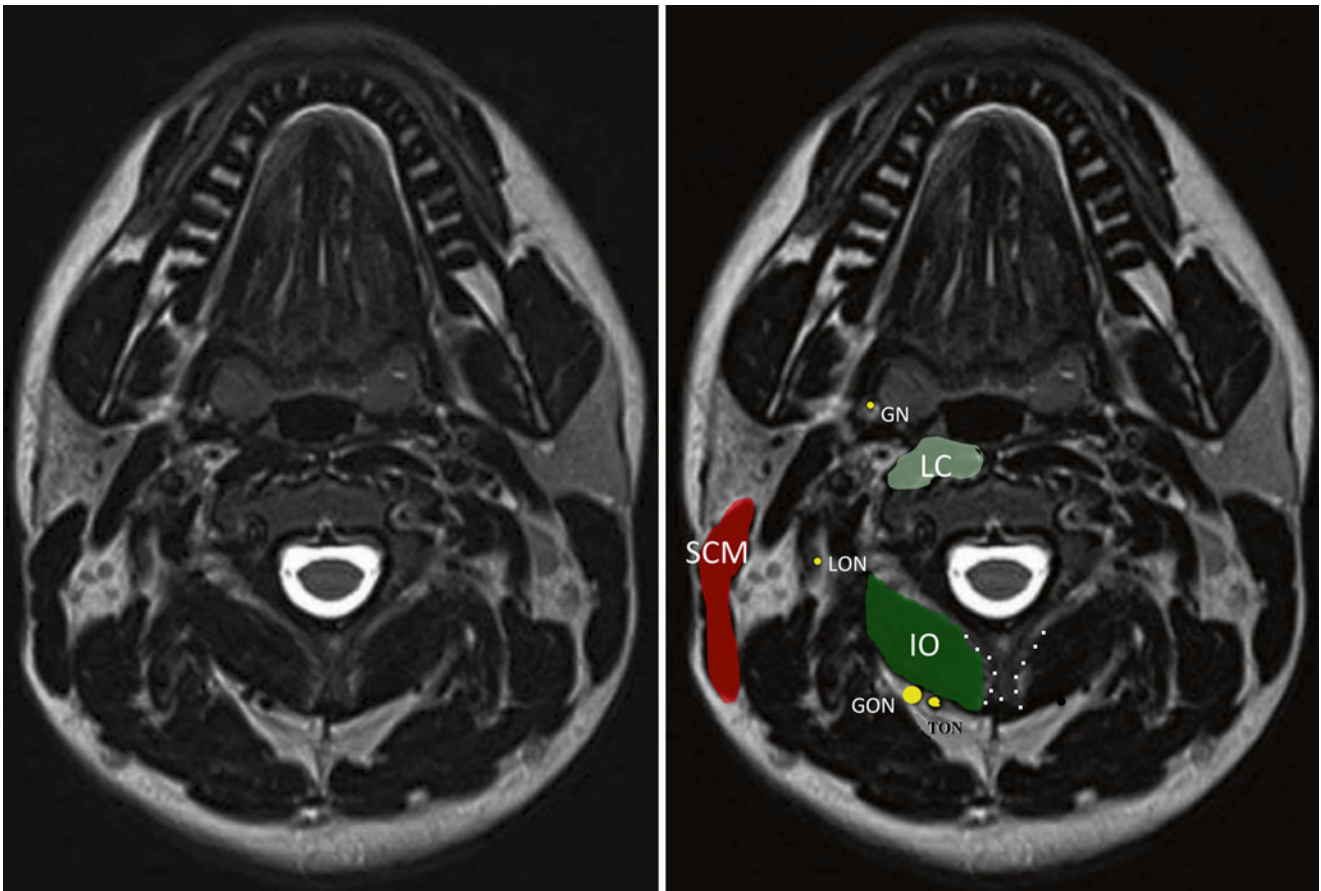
MRI image showing the location of the third occipital nerve, noting the bifid spinous process (Image courtesy of Andrea Trescot, MD; adapted from Galliano et al. [25])
